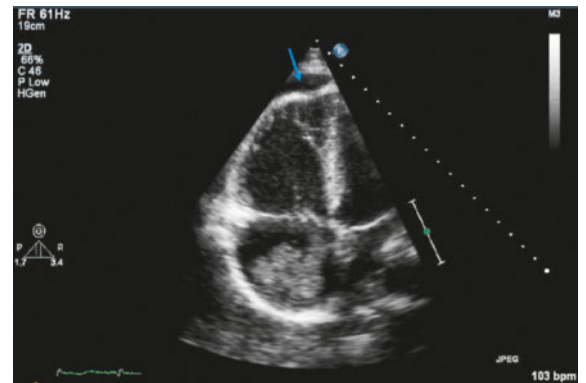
Modified apical four chamber view with focus on the right ventricle in a patient suffering from acute pulmonary embolism due to embolisation of right atrial myxoma. Dilated right ventricle with typical configuration due to hypercontractile apex and hypo/akinesia of the mid-wall region (McConnell's sign; arrow).
